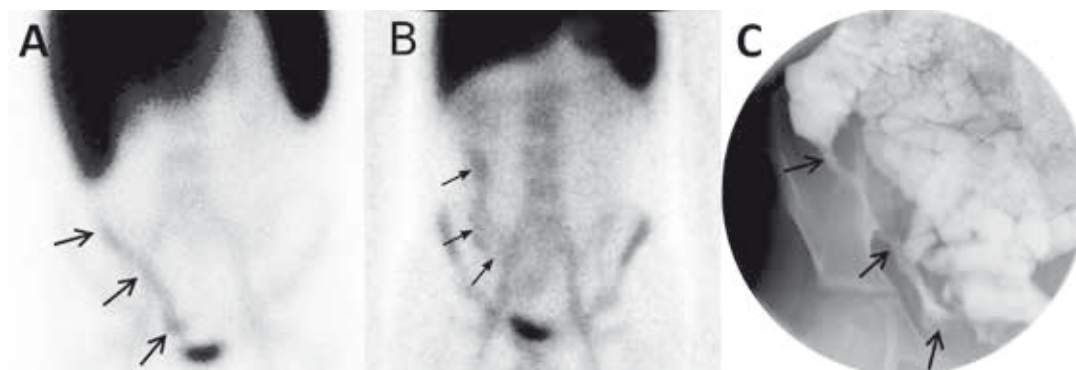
Crohn's disease with ileocecal involvement. An early scintigram in a 12-year-old boy with a pathologic accumulation of labeled leukocytes in the right lower abdominal quadrant corresponding with the location of the terminal ileum, caecum, and the ascending colon (Cheow score 3C) confirms the presence of Crohn's disease (A). A late scintigram with even more conspicuous pathologic accumulation (Cheow score 3C) in the same location (B). Small bowel follow through in the same boy shows cobblestoning and irregular luminal narrowing as typical features of Crohn's disease in the terminal ileum, caecum and the ascending colon using MR enterography (C)
